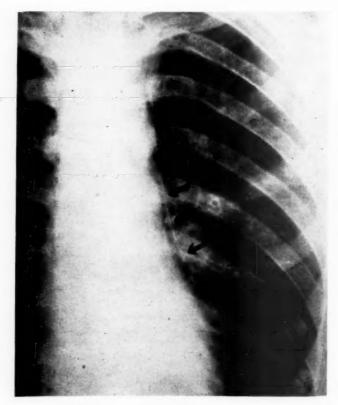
Roentgenogram of chest demonstrating air in the mediastinum.
